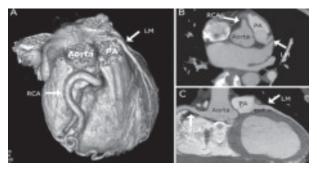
CT angiogram of ALCAPA
